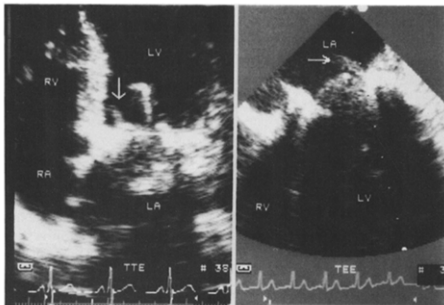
Left, Transthoracic (TTE) apical four-chamber view demonstrating a vegetation (arrow) on the left ventricular side of the mitral prosthesis. Right, The transesophageal (TEE) four-chamber view shows a vegetation (arrow) at the sewing ring of the valve apparatus protruding into the left atrium. See text for details. RV = right ventricle; other abbreviations as in Figures 1 and 2.
